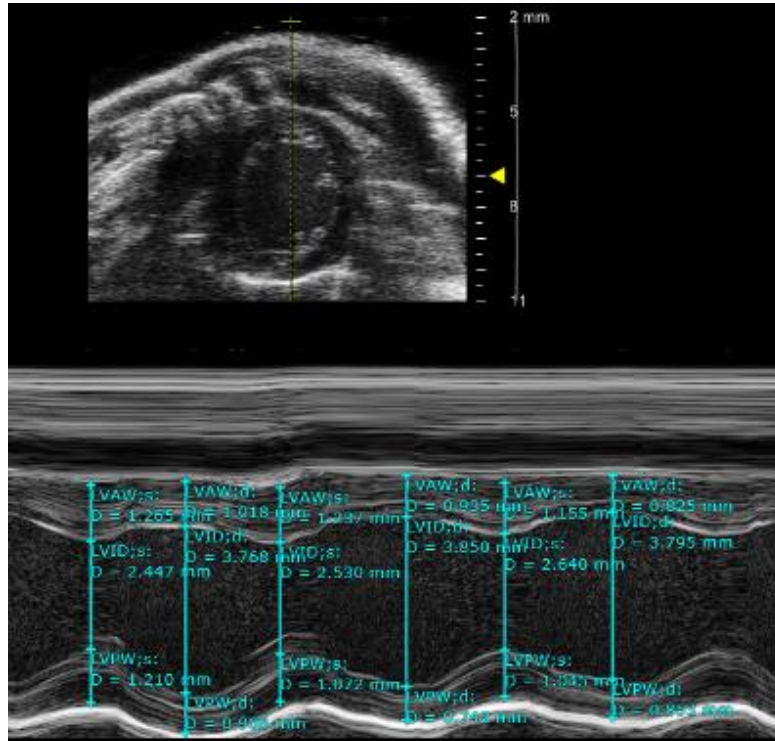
M-Mode of parasternal short-axis view, at the papillary muscle level.
